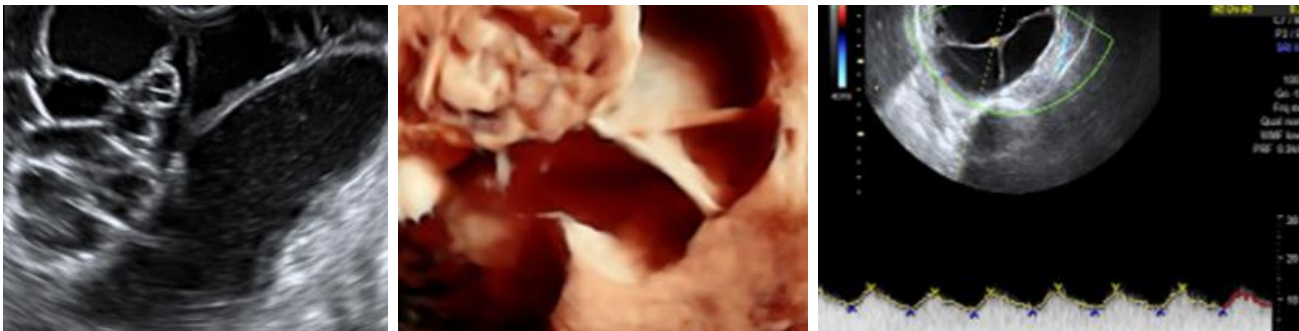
A case of women with Hugh tumor formation at post menopause: 2D/3D and color Doppler ultrasound: Multilocular-solid cyst, irregular cyst wall, dimension > 15 cm; multiple vascularized septa Ri<0,40 PH: Cystadenoma border line
